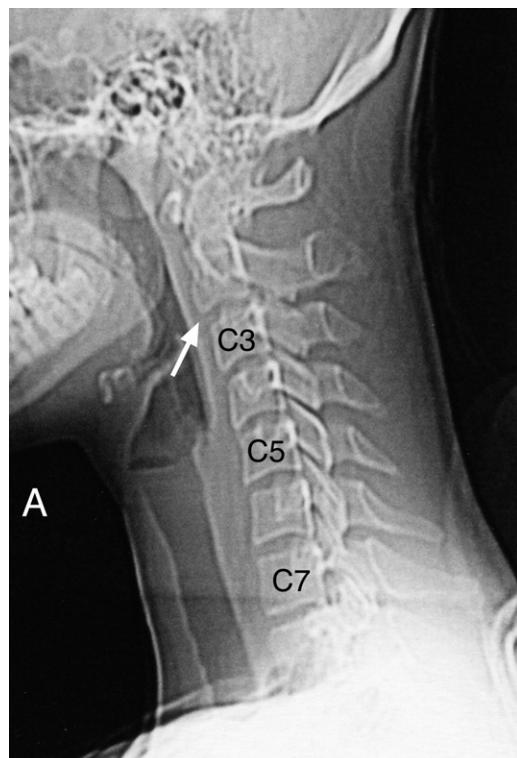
Cervical spine CT lateral scout image. Note the loss of normal cervical spine lordosis with a cervical spine kyphosis and an apex at approximately the C5 level. In addition, there appears to be a degree of anterolisthesis of C2 on C3 (white arrow). There is no lipping of the vertebral body margins to suggest an injury of longstanding.
